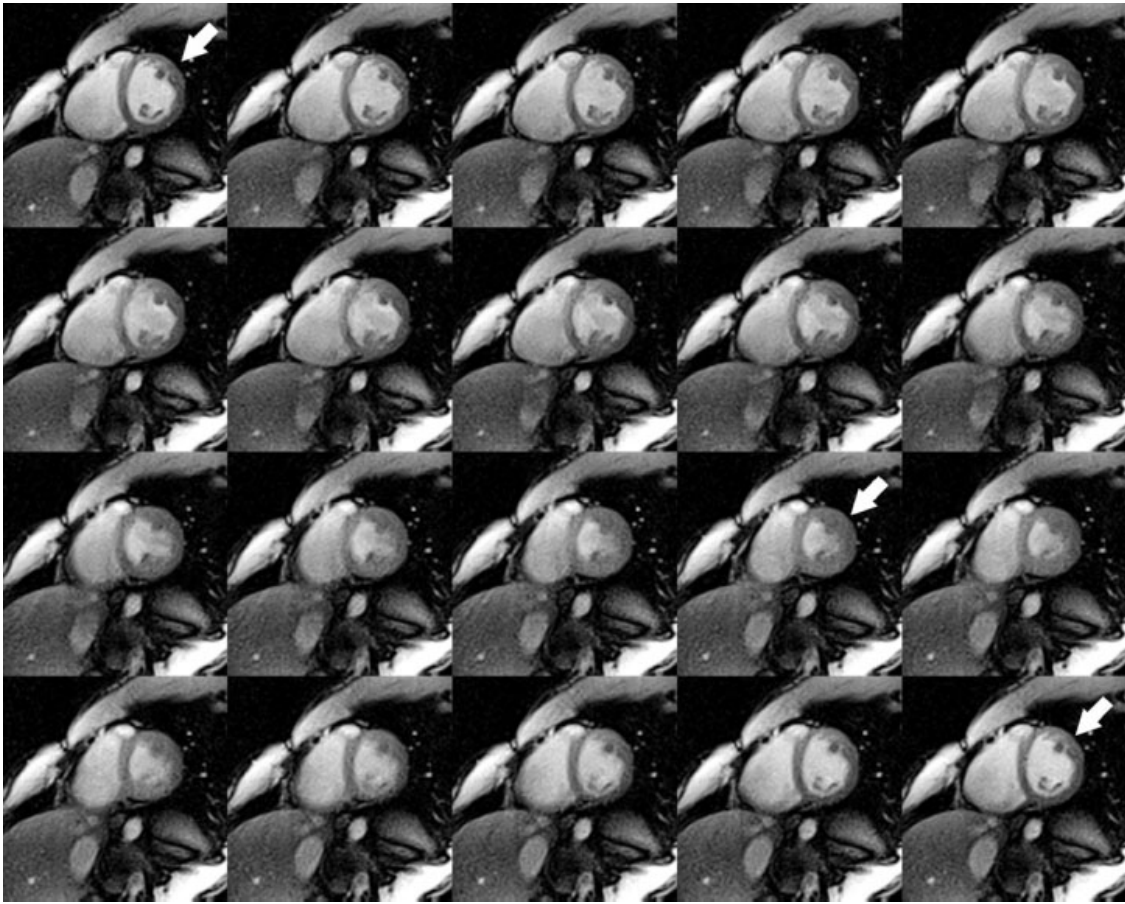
Real-time MRI of the heart at 20 Hz frame rate. The images (top left to lower right) were obtained from a healthy subject in a short-axis orientation using a spoiled radial FLASH sequence at 2 mm in-plane resolution and 8-mm section thickness (TR/TE = 2.02/1.30 msec, flip angle 8°, 256 mm FOV, base resolution 128, 125 spokes, image update every 25 spokes, compression to 8 channels). The image series corresponds to a 1-second period covering a full cardiac cycle from end-diastole to systole and the next diastolic phase (arrows) at 50 msec temporal resolution.
